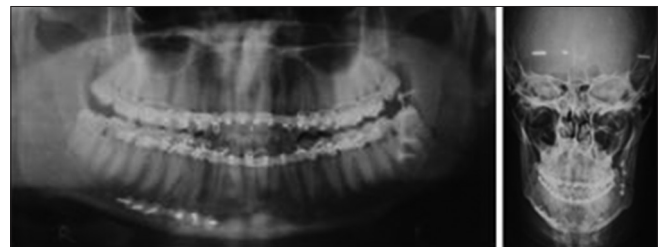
Postoperative OPG X-ray
